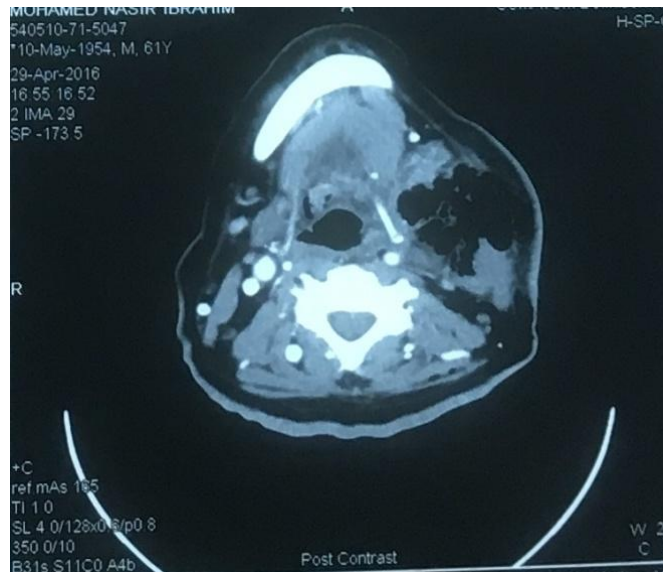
CT Image Of Neck showing gas collection in the soft tissue over left side of the neck
